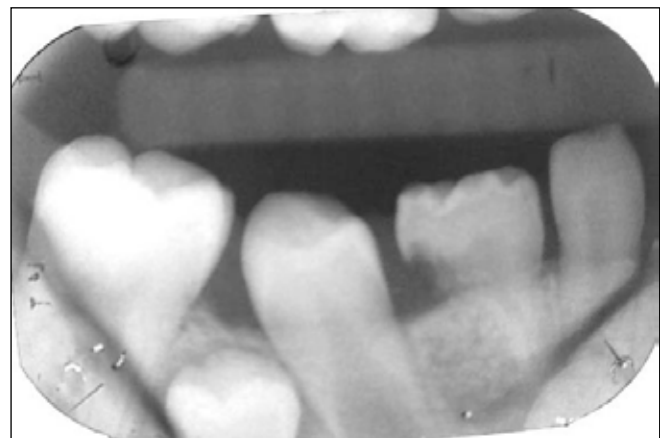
Right bite-wing radiograph, demonstrating deep and extensive caries and periradicular bone resorption of the mandibular primary second molar.
